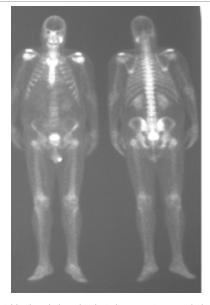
Total body scintigraphy that shows a strong pathological incensement of the tracer on the condyle mandibular left and part of mandible ascending ramus.
